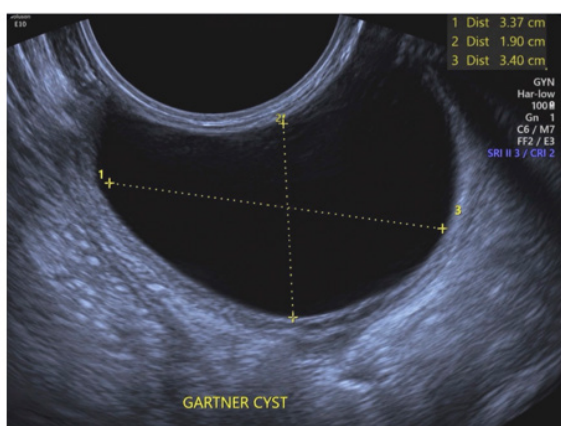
Ultrasonographic image of Gartner's duct cyst located in the left vaginal lateral wall, measuring $32 \times 21 \times 42$ mm, larger than average values reported in the literature.
